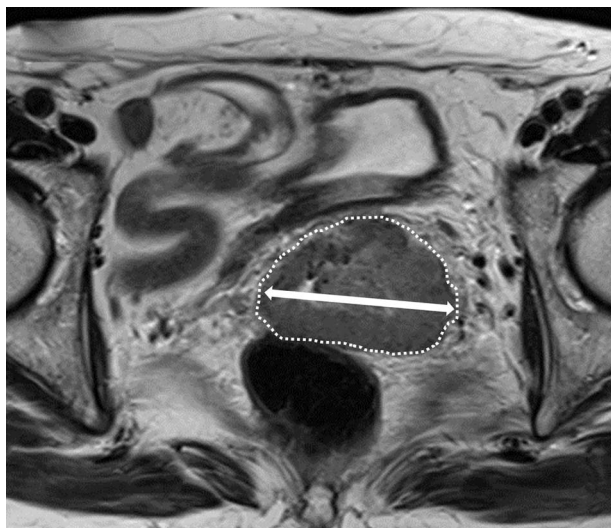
The horizontal tumor diameters were measured based on the axial T2-weighted MRI.
